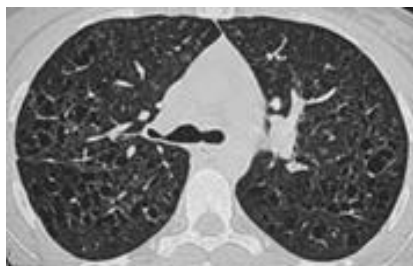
HRCT appearance of pulmonary Langerhans cell histiocytosis (LCH)
